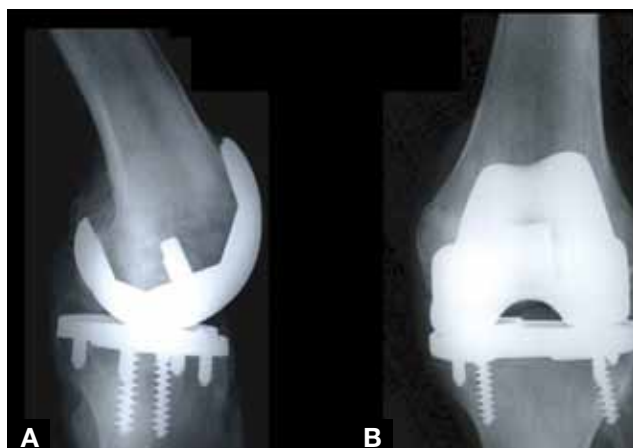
(A, B) Postmortem contact radiographs from 85-year-old female donor at 25-year follow-up.
